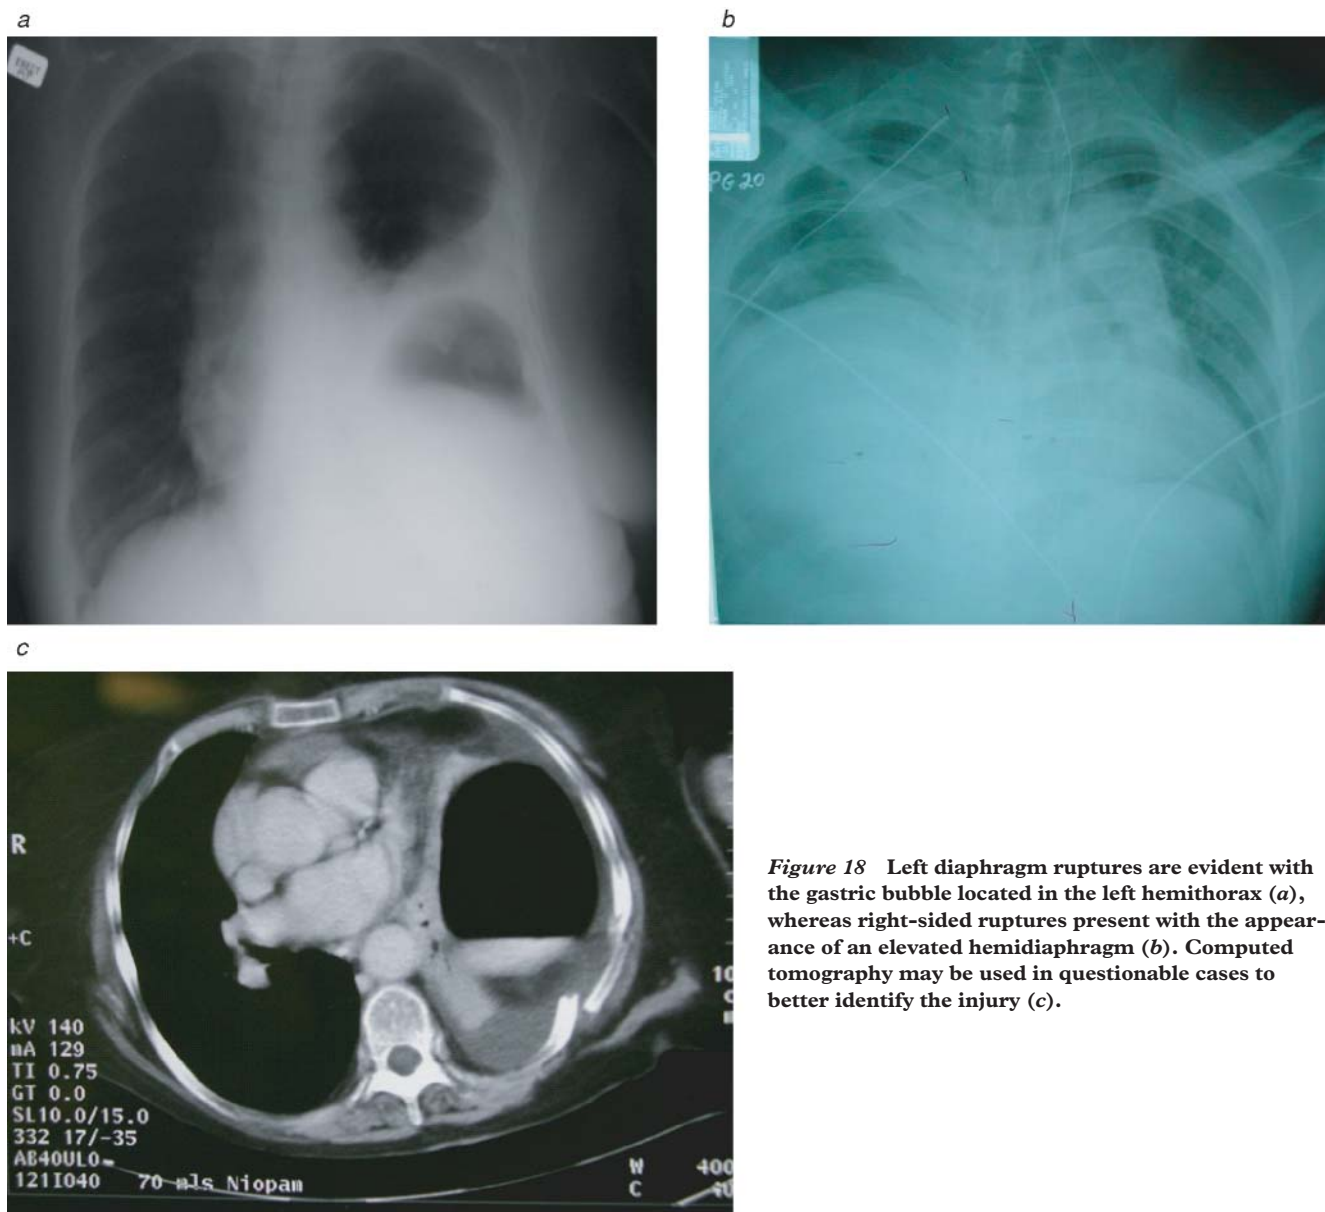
Left diaphragm ruptures are evident with the gastric bubble located in the left hemithorax (a), whereas right-sided ruptures present with the appearance of an elevated hemidiaphragm (b). Computed tomography may be used in questionable cases to better identify the injury (c).
